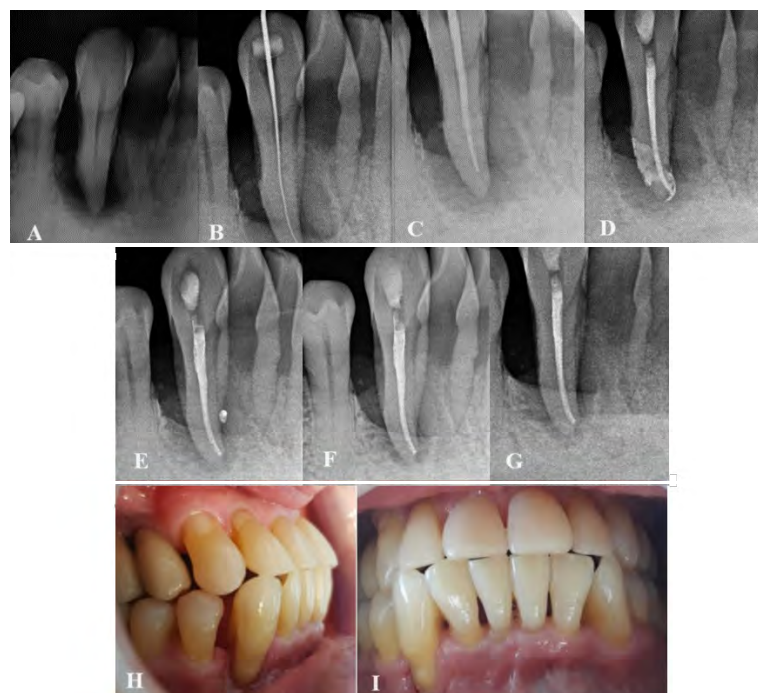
A: Element 43 with an extensive lesion; B: Working length; C: Master cone test; D: Obturation and final radiograph; E: 6-month follow-up; F: 12-month follow-up; G: 18-month follow-up; H and I: Current clinical photograph after endodontic and periodontal treatments.
